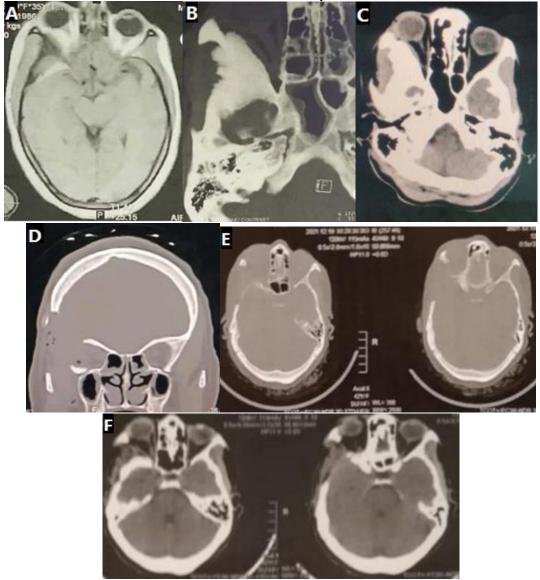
preoperative and postoperative images of a 45-year-old female patient presented with proptosis and headache, subjected to excision through a right frontotemporal craniotomy with good results and improvement of proptosis. A: MRI T1 contrast showing proptosis and thin enhancing sheet of tumor
